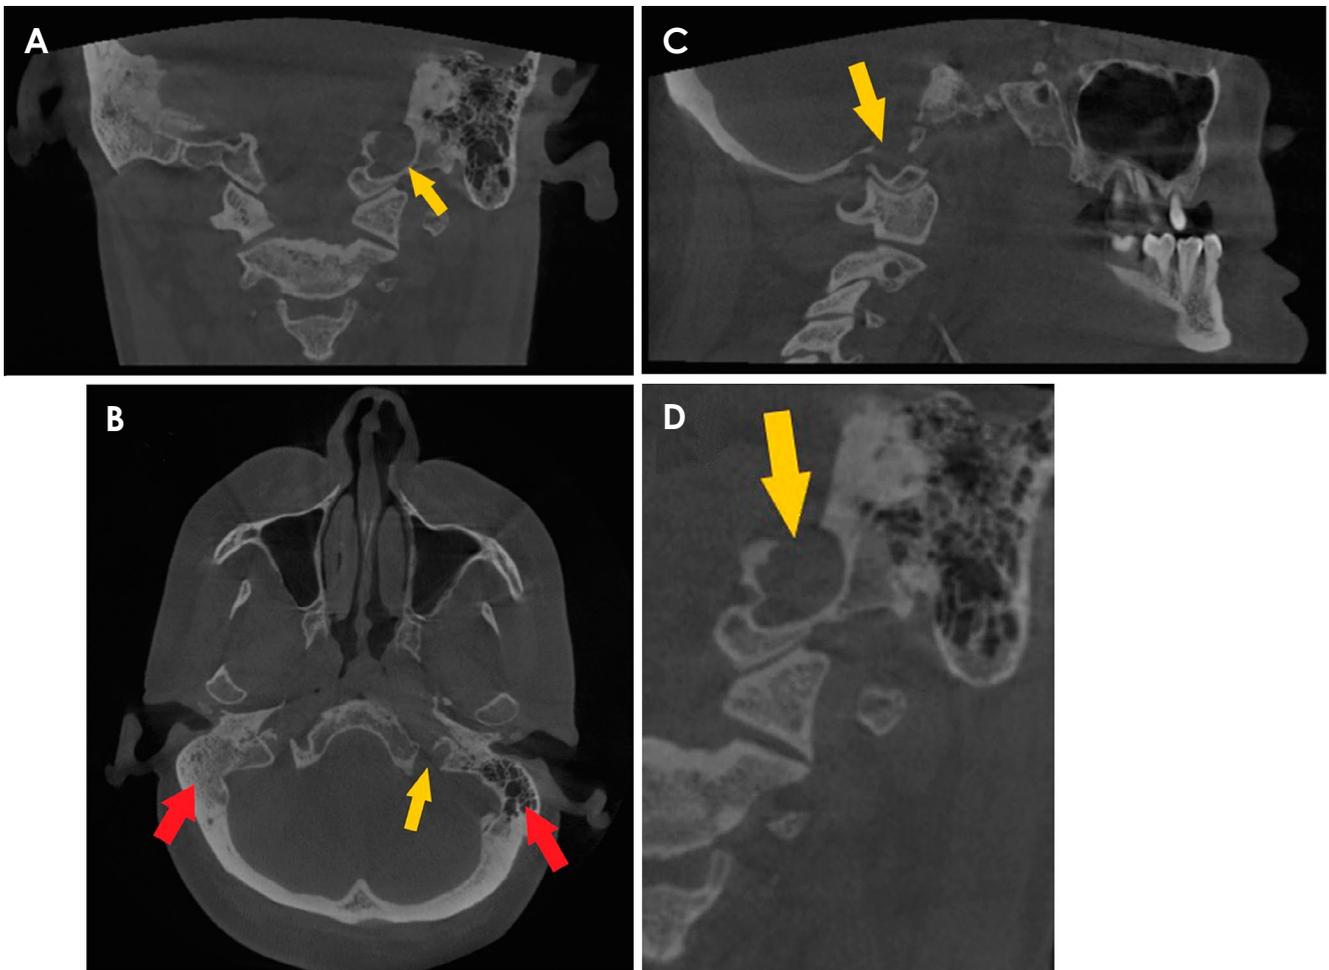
A. A coronal cone-beam computed tomographic (CBCT) image depicts extension of the left jugular bulb into the ipsilateral occipital condyle. B. An axial CBCT image demonstrates maintenance of the jugular spine (yellow arrow) and well-aerated mastoid air cells on the left side compared to those on the contralateral side (red arrows). C. A sagittal CBCT image shows irregular expansion of the jugular bulb into the occipital condyle. D. A sagittal CBCT image clearly indicates a dilated jugular bulb.
